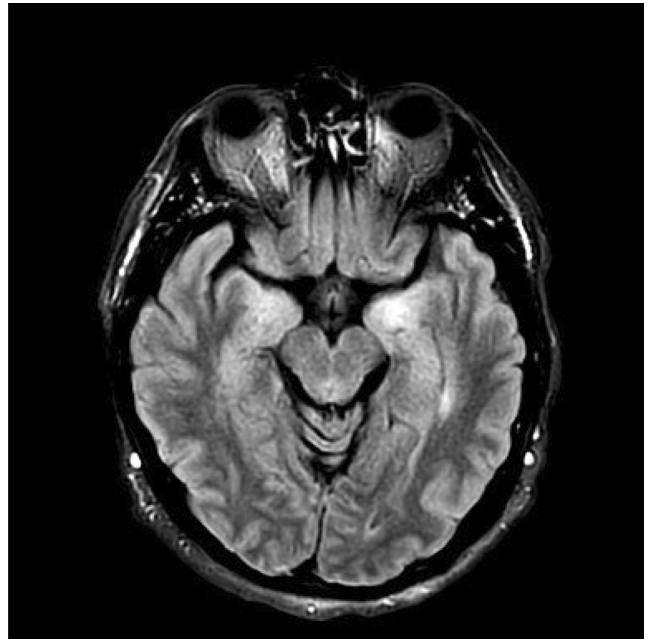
Brain RM T2-FLAIR revealing hyperintensities in bilateral temporomesial regions.
